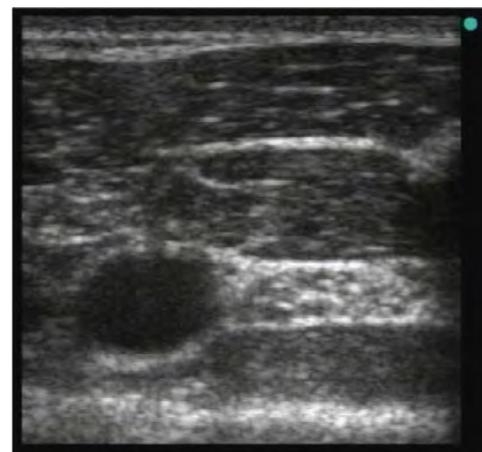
Ultrasound of the infraclavicular plexus
